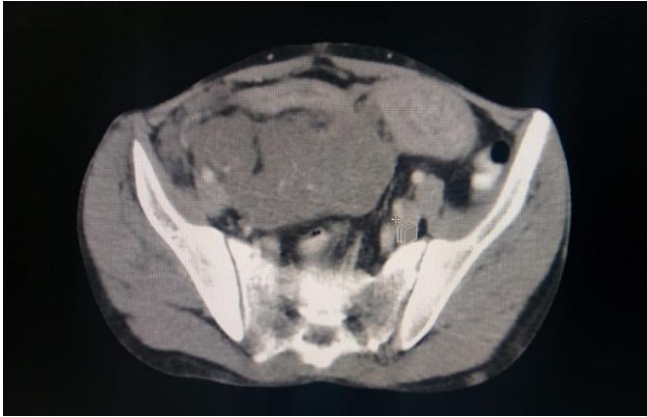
CT abdomen showing large non enhancing matted nodular mass seen in mid abdomen
